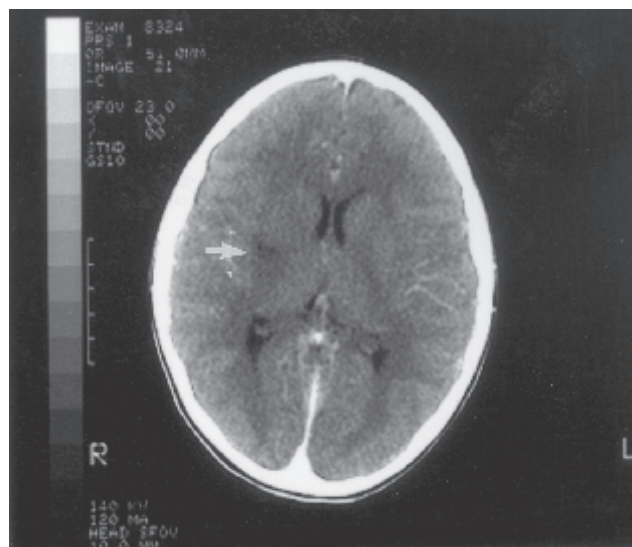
Enhanced CT, 9 days after onset of symptoms, demonstrating acute ischemic infarction in the right lentiform nucleus and anterior part of the right internal capsule (arrow).
